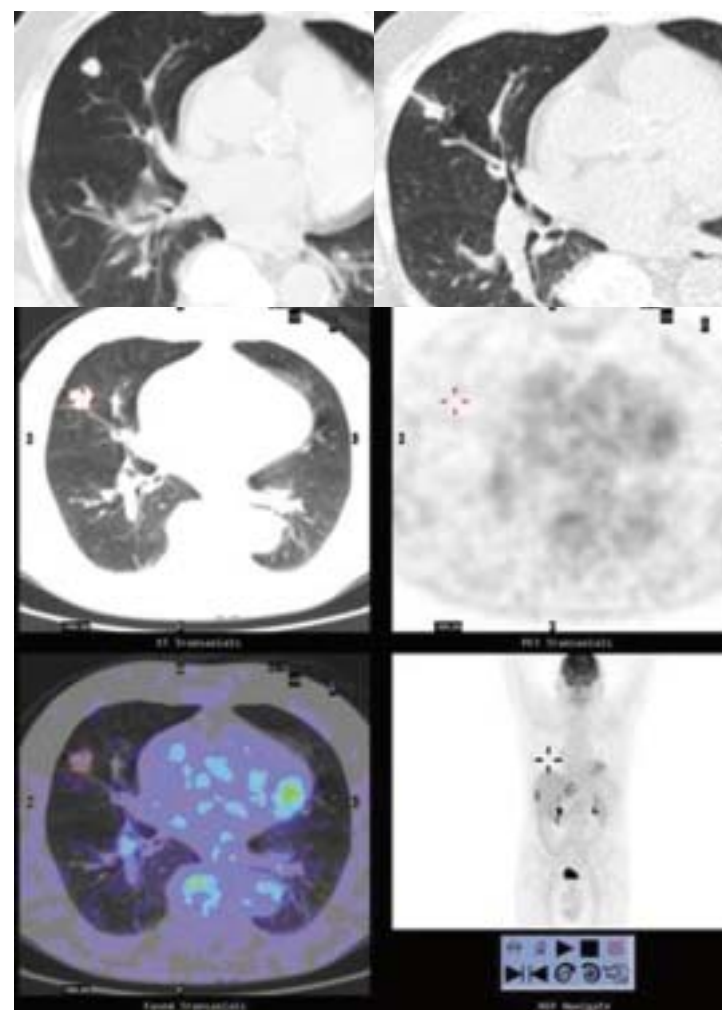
Lung colo-rectal metastasis treated by RF ablation. 6 Months later the lesion remained nodular and larger than before the treatment, PET indicates that a complete ablation was achieved with no captation of 18 F-FDG inside the nodule
